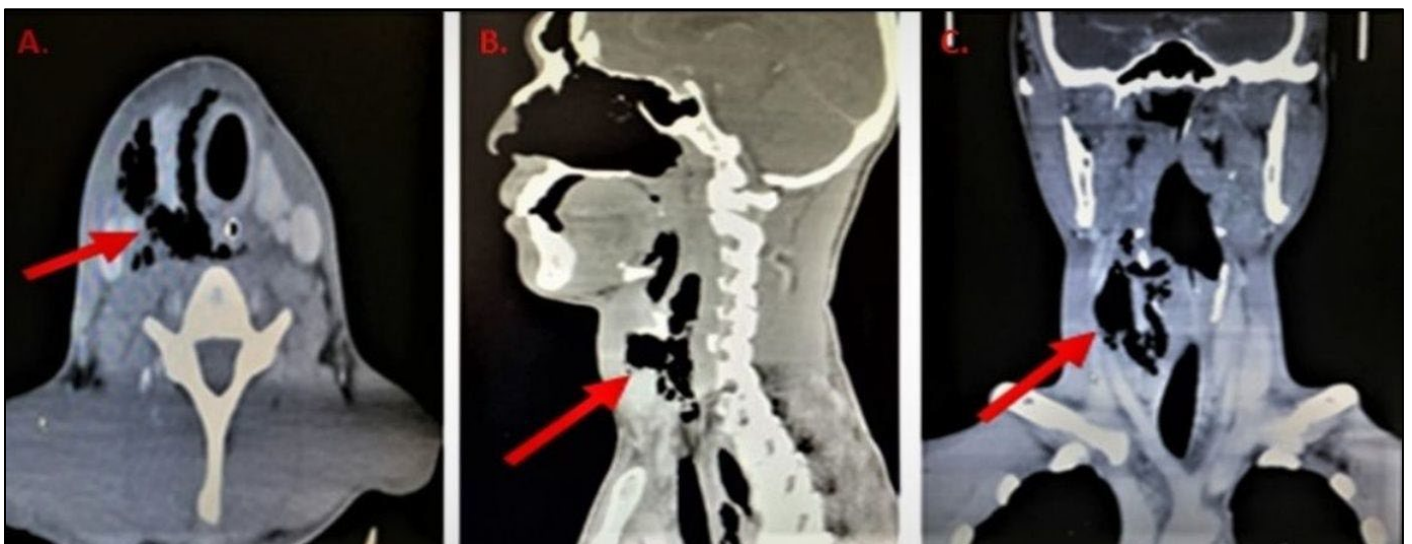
Axial (A), sagittal (B) and coronal (C) cut of CT neck showing air collection (red arrow) on the right side of the neck
